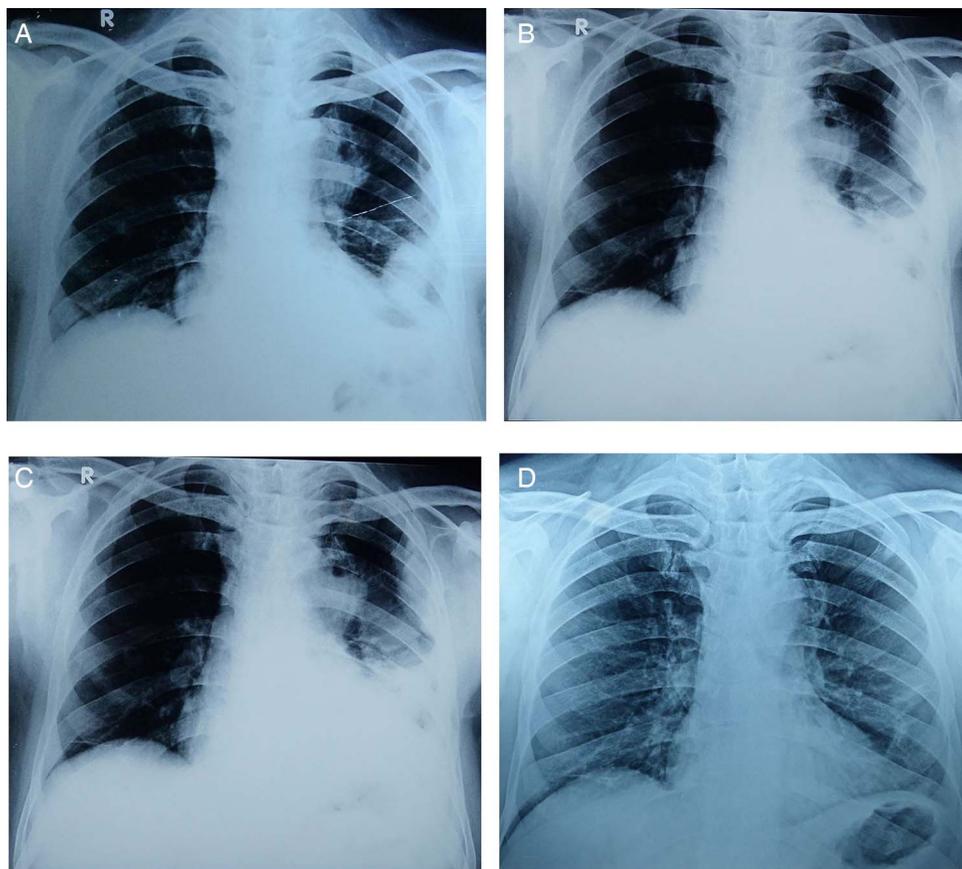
Chest X-ray (A) on the day of admission showing well-defined nodular shadow in the left lower lung zone and (B) on day 10 after admission showing increase in left lower zone shadows, with the left middle zone shadow in the parahilar region becoming prominent. (C) Chest X-ray 4 weeks after starting therapy for *Nocardia* and *Aspergillus*, showing resolving left lower zone shadows, with the left middle zone shadow having disappeared. (D) Chest X-ray 4 months after starting therapy for *Nocardia* and *Aspergillus*, showing almost complete resolution of previous shadows.
